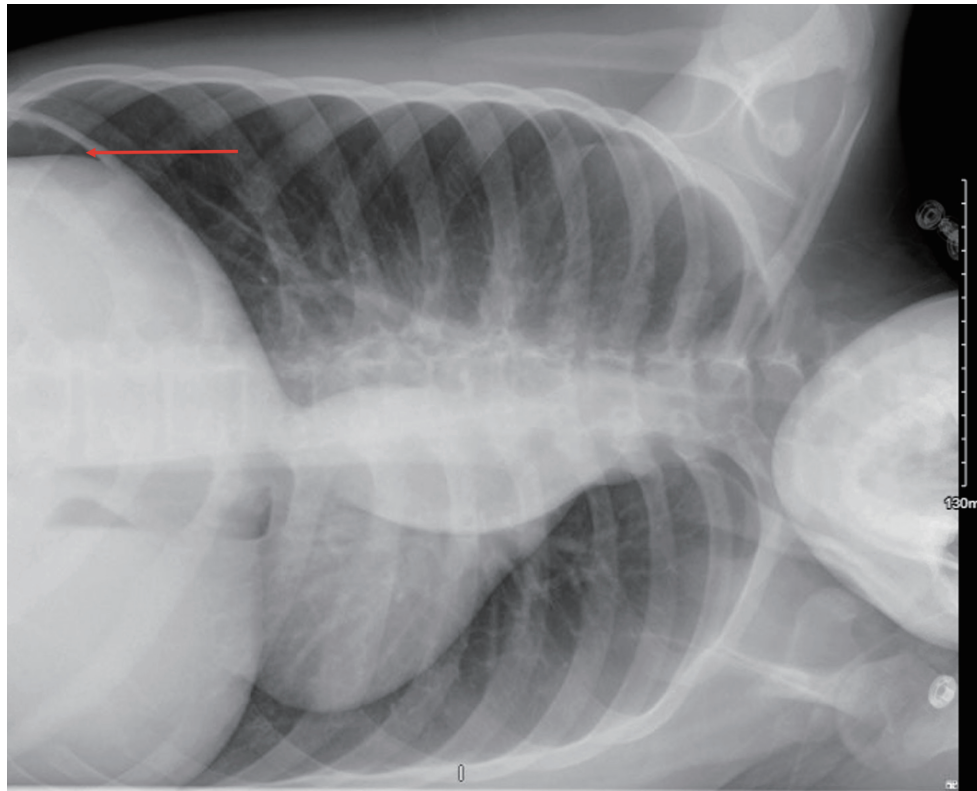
Postoperative chest X-ray demonstrating residual pneumoperitoneum following laparoscopic procedure. Chest X-ray obtained on postoperative day 1 for evaluation of abdominal pain. A small amount of nondependent air is identified beneath the diaphragm (red arrow) (left lateral decubitus position demonstrating free air above the liver), consistent with residual pneumoperitoneum following a recent laparoscopic procedure.
